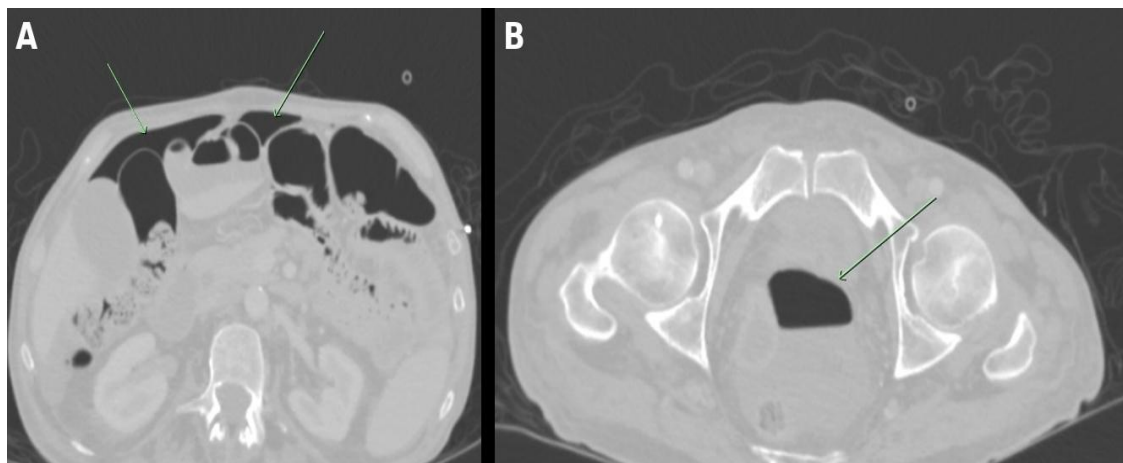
(A and B): Axial computed tomography of the abdomen and pelvis at the onset of acute abdominal pain. (A) Upper abdomen, demonstrating moderate to large volume free intraperitoneal gas collecting anteriorly beneath the anterior abdominal wall (arrows). (B) Pelvis, demonstrating a further loculated collection of free intraperitoneal gas (arrow). The findings are consistent with hollow viscus perforation.
